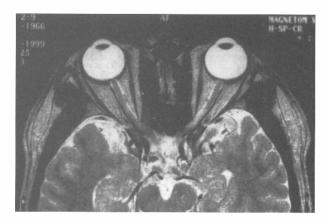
T2-weighted MRI scan disclosed enhancement of the left optic nerve.
